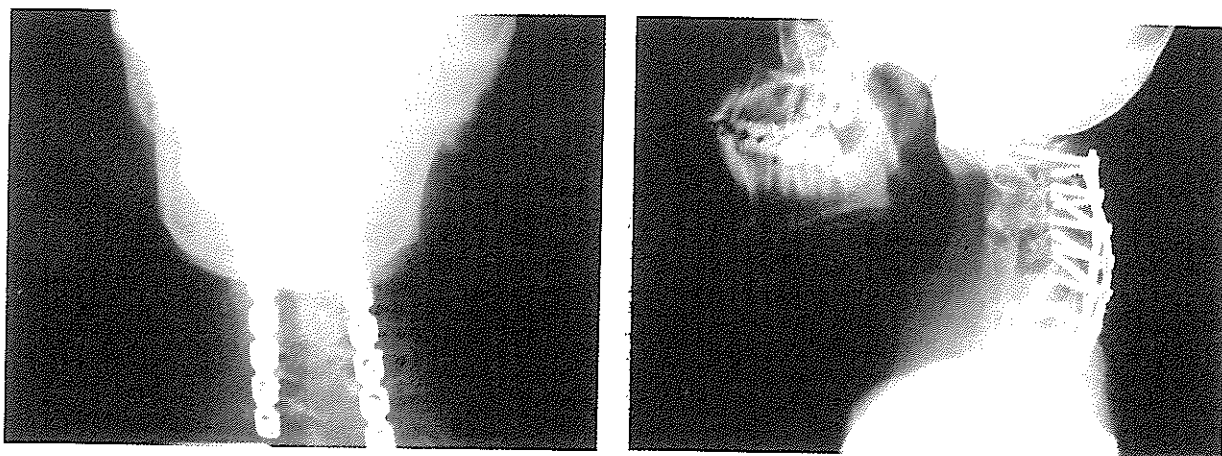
Radiographs at the sixth month of follow-up of the neurofibromatosis case that was treated by combined fusion.
